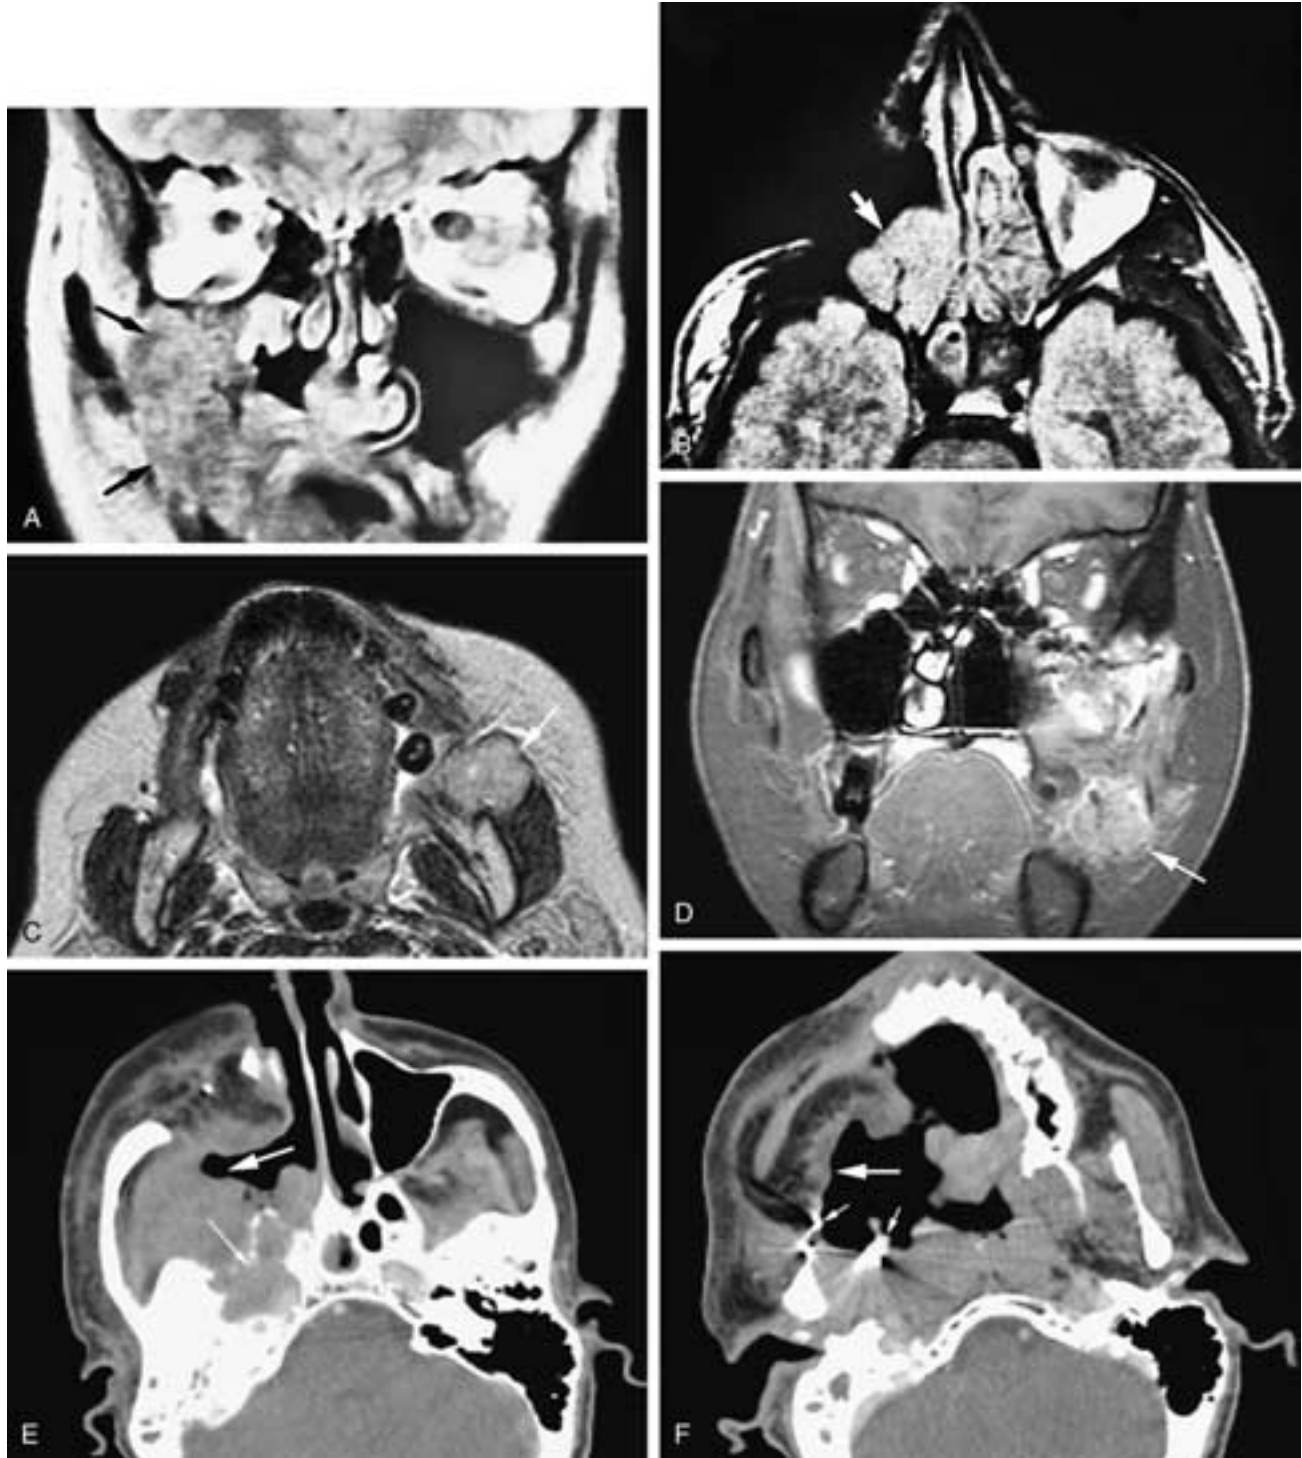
Coronal proton density MR image (A) shows a large right recurrent tumor with an intermediate signal intensity (*arrows*) in a patient who has had a total right maxillectomy. Axial proton density MR image (B) shows a patient who has had a total right orbital exenteration and a total maxillectomy. Tumor recurrence is seen in the right orbital apex (*arrow*). Axial FSE T2-weighted (C) and coronal T1-weighted, fat-suppressed, contrast-enhanced MR image (D) on a different patient who has had a left maxillectomy with a graft reconstruction. A tumor nodule is seen at the lower lateral margin of the graft (*arrows*). This was not clinically evident and points out the value of surveillance imaging. Axial CT scans (E, F) on another patient who has had a right total maxillectomy with a flap reconstruction. Tumor is present along the upper margin of the flap, eroding the skull base (*thin arrow*). Tumor fills the flap, and the medial side of the flap has become necrotic and ulcerated (*large arrow*). In (F), surgical clips that were within the flap are now exposed (*small arrows*) at the necrotic surface of the flap.
